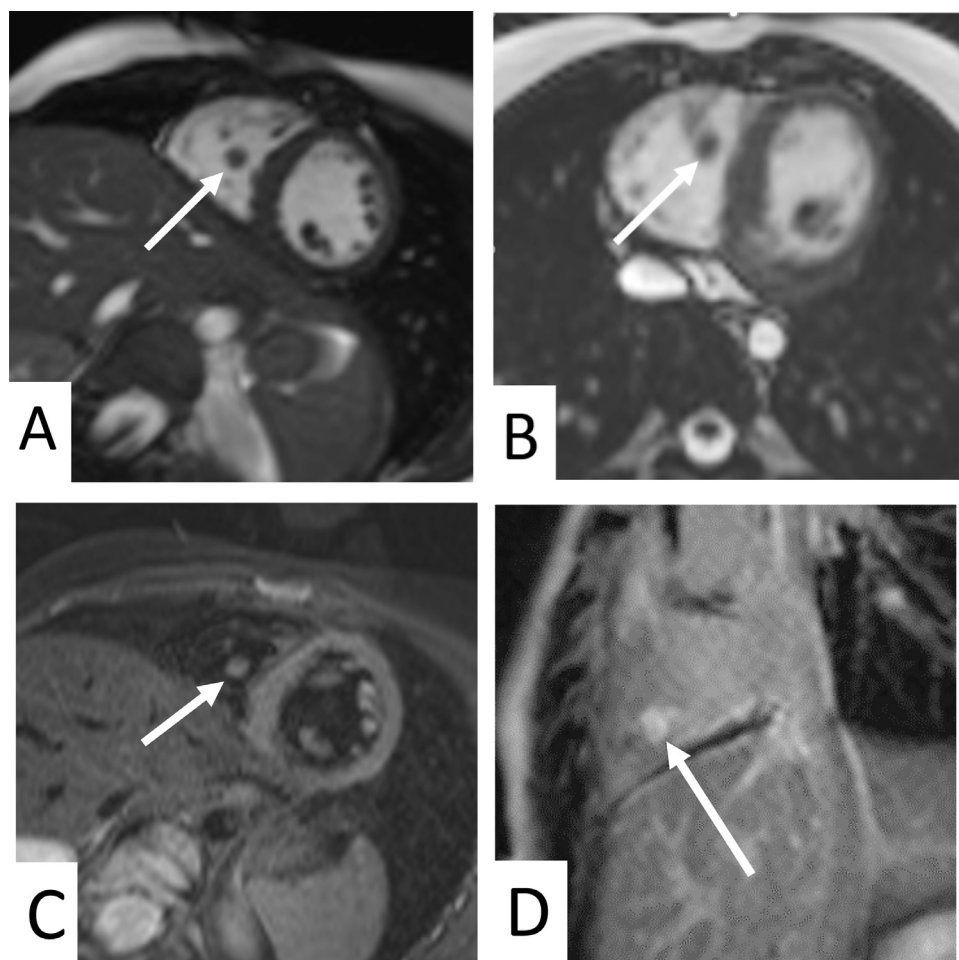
CMRI. Balanced steady-state free-precession (BSSFP) cine images in SAX (A) and axial (B) plane confirm the presence of a right intracavitary nodular lesion with a diameter of 6 mm (arrow). T2w TSE image in SAX plane (C) reveals isointense signal of the lesion in comparison to ventricular wall. Intense contrast agent uptake can be seen in sagittal postgadolinium MDE image (D). CMRI, cardiac magnetic resonance imaging; MDE, myocardial delayed enhancement; SAX, short-axis; TSE, turbo spin echo.
